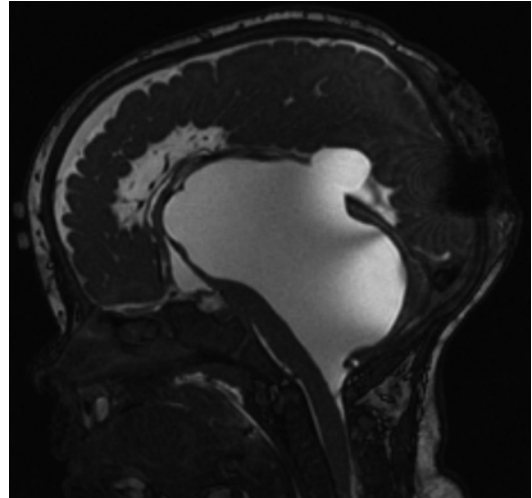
T2-weighted MRI of a 16-month-old patient with a history of prematurity and PHH and multiple CSF infections. There is a loculated fourth ventricle with outlet obstruction with considerable mass effect on the brainstem and cerebellum. There is also supratentorial extension
